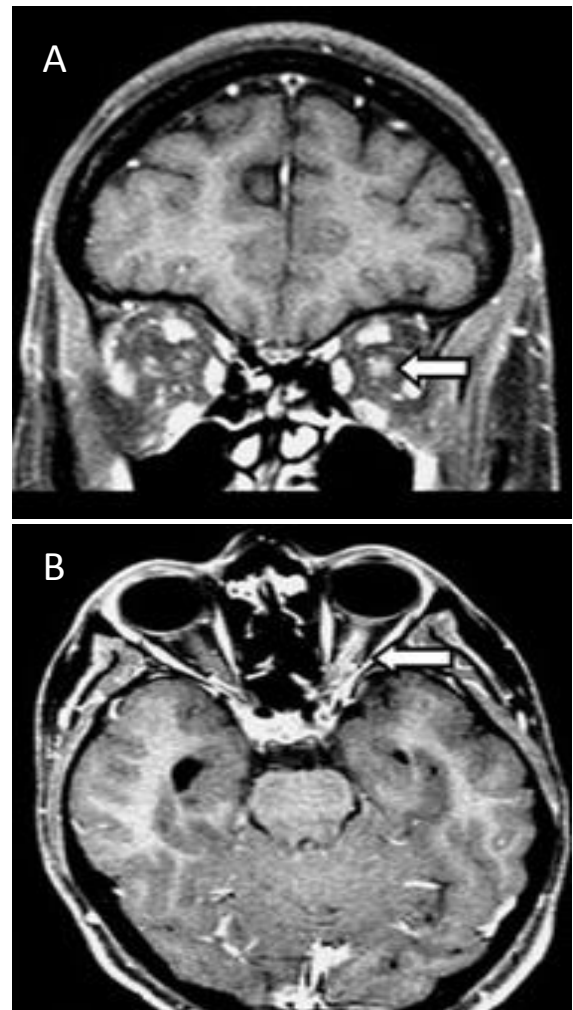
A. Contrast-enhanced T1-weighted, fat-suppressed coronal MRI through the orbits shows contrast enhancement of the left optic nerve (arrow). B. Contrast-enhanced fat-suppressed axial MRI through the orbits shows contrast enhancement of the left optic (arrow).
